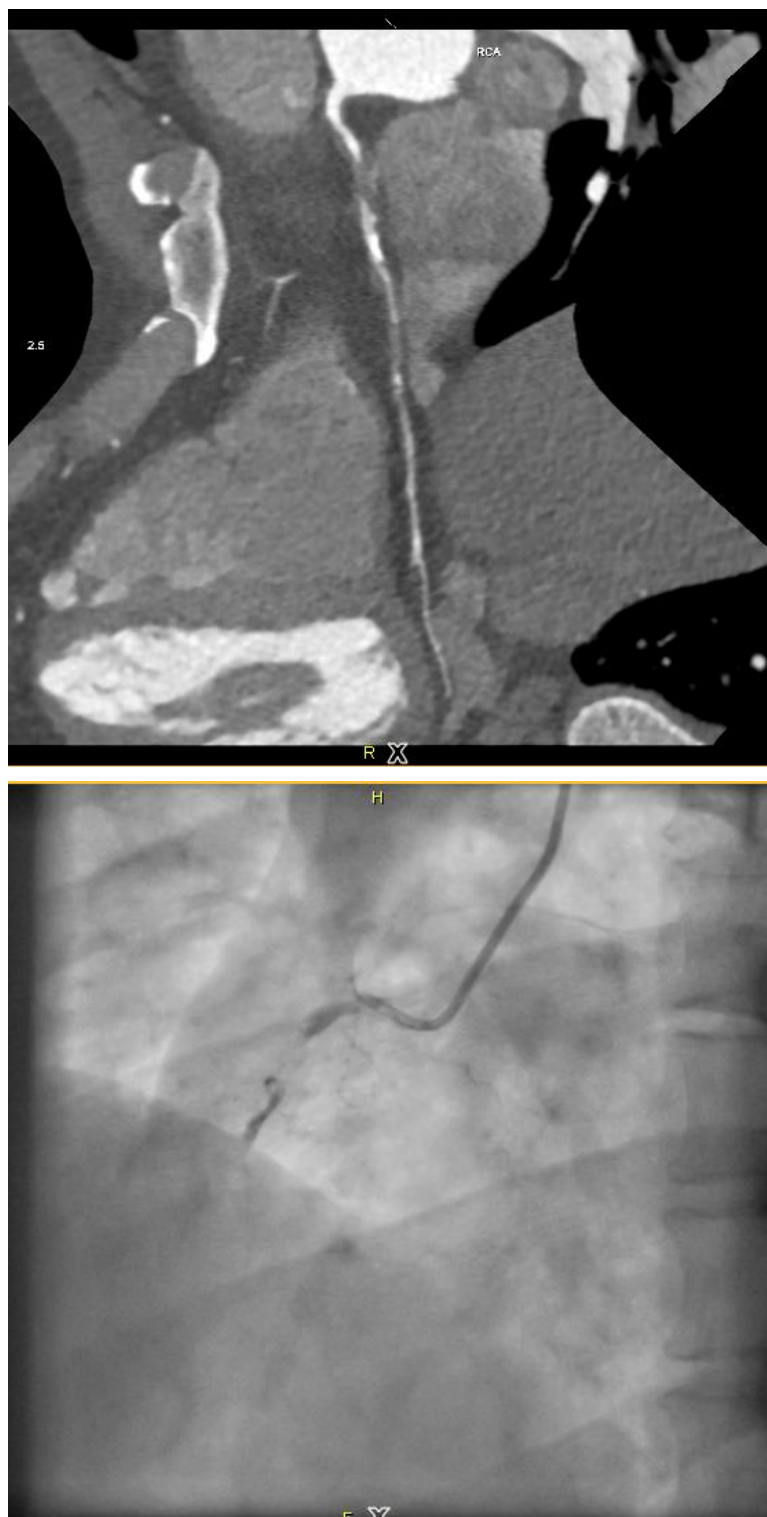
catheter angiogram and CT image of RCA showing severe stenosis in the distal segment
